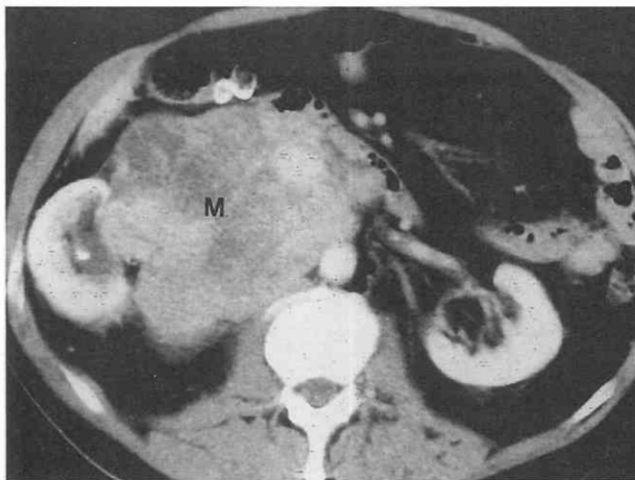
Leiomyosarcoma. Contrast-enhanced CT image at the midabdomen level in a 65-year-old man shows a large retroperitoneal mass (M) on the right. At surgery, this mass, which was subsequently determined to represent a leiomyosarcoma, was found to have invaded the inferior vena cava and right kidney. Any non-fat-containing primary retroperitoneal malignancy cell type may have this appearance.
